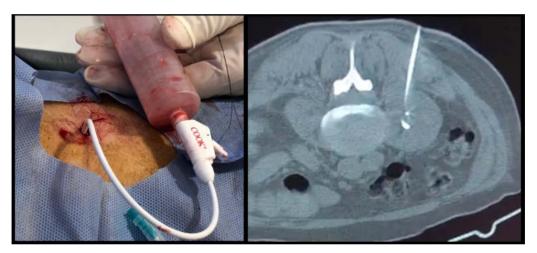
Computed tomography-guided percutaneous drainage.
